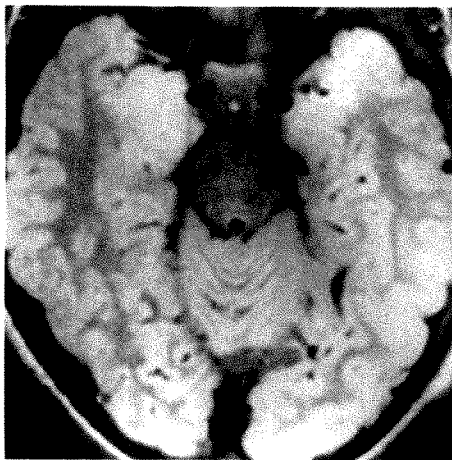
Oligodendroglioma in an 11-year-old boy. Intermediate-weighted transaxial MR image shows right mesial temporal abnormal high signal involving gray and white matter diffusely. Pathologically, tumor was cellular without calcification and involved all of the amygdala and uncus with extension into hippocampus.
